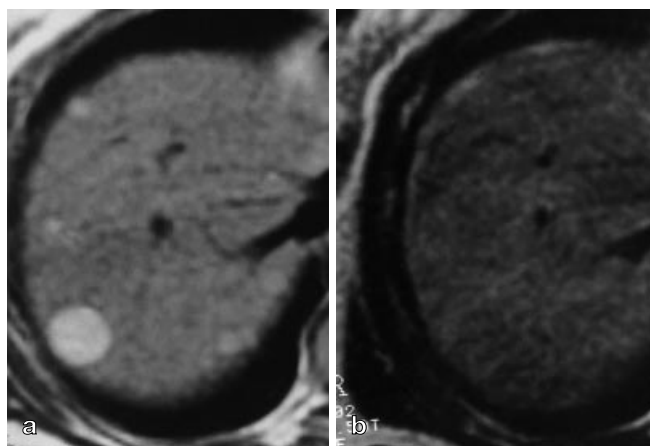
a Glycogen accumulation within macroregenerative nodules in cirrhosis give a markedly high signal intensity on T1-weighted MR images. b The lesions are isointense to liver on T2-weighted image
